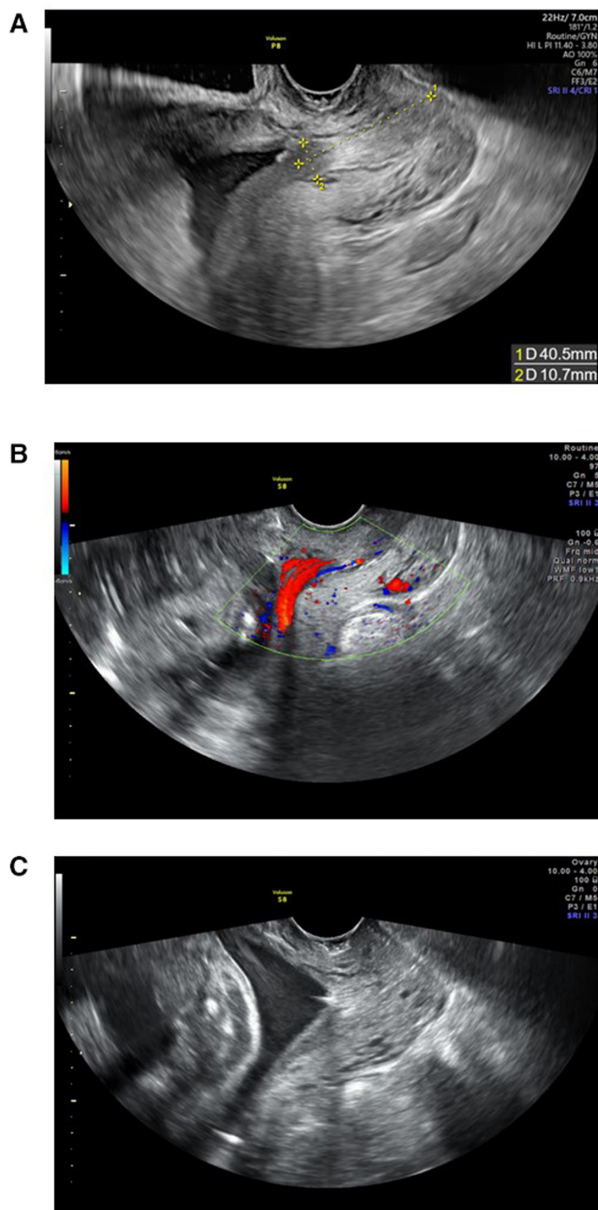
(A, B) The vascularised stalk of the polyp was visualised in the cervical canal by ultrasonography. (C) The cervical polyp retracted into the uterus and disappeared at 28 WG by ultrasonography. WG, weeks of gestation.
